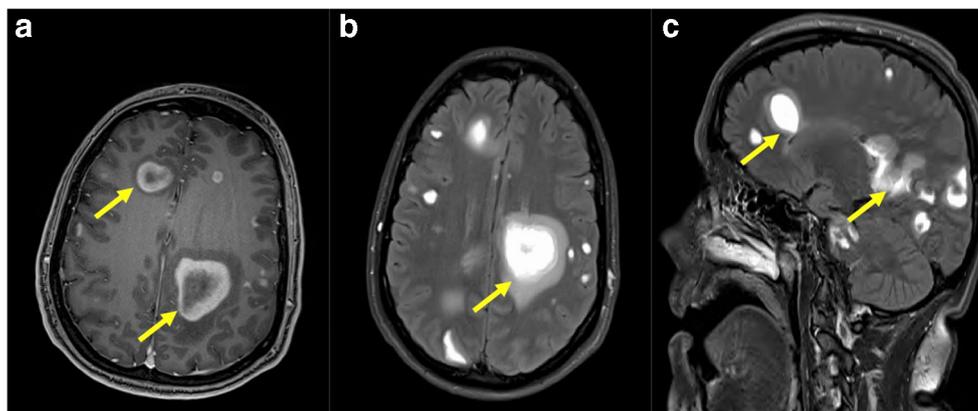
MRI brain scan from a patient with relapsing remitting MS and an encephalopathic presentation. a Axial T1-weighted image with gadolinium enhancement, showing ring enhancing lesion, b axial fluid attenuated inversion recovery (FLAIR) image demonstrating
